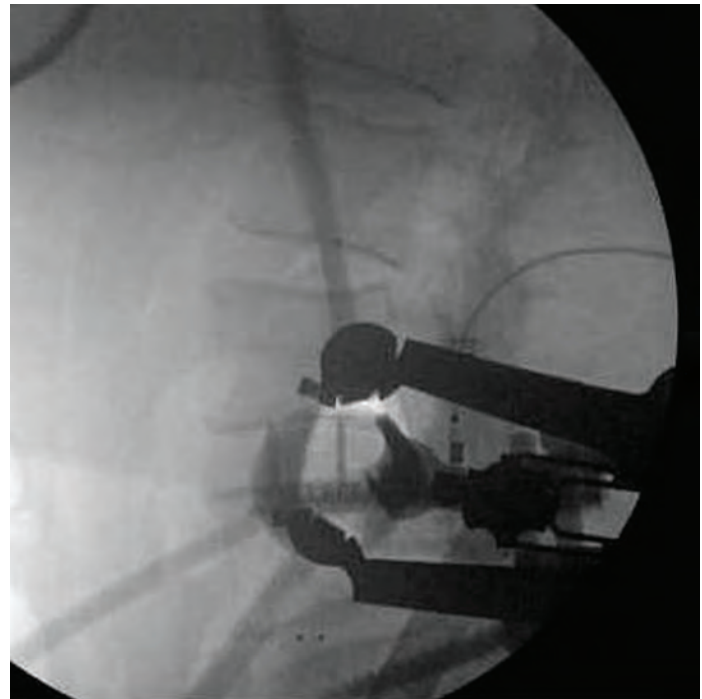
Fluoroscopic (x-ray) image taken during a procedure. This imaging technique allows the surgeon to visualize the structures on a screen to accurately perform the minimally invasive surgery procedures. Here, the hardware seen on the right side of the image are the retractors.
